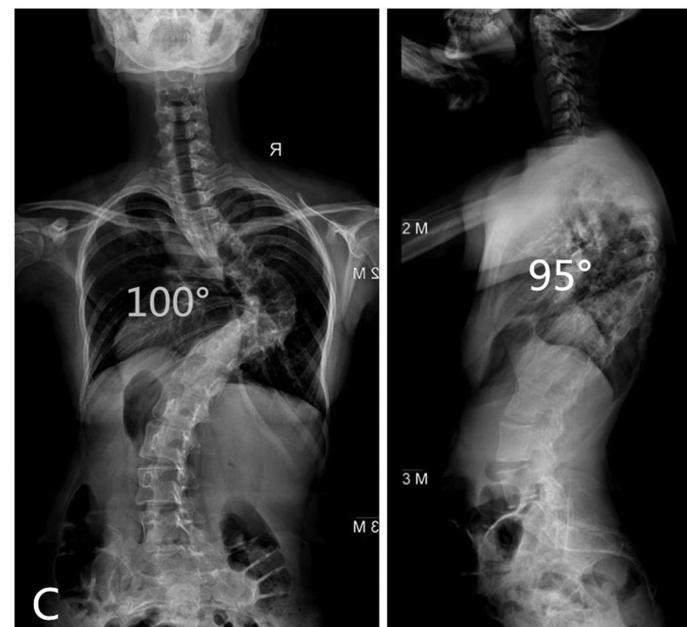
Long-standing scoliosis radiographs showed that the coronal and thoracic kyphosis Cobb's angles were 100° and 95°, respectively, one year after implant removal.
